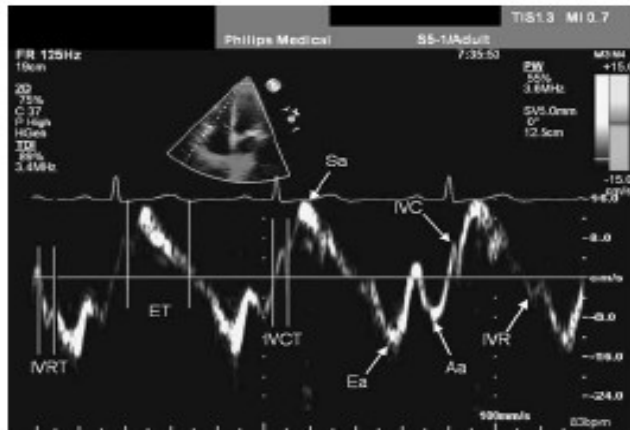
Tissue Doppler profile of the right ventricle in a healthy young adult. The normal velocities in this subject using tissue Doppler pulsed spectral imaging are: $Sa(S) = 16$ cm/sec, $Ea(E') = 15$ cm/sec, and $Aa(A') = 10$ cm/sec. Aa = late diastolic velocity; Ea = early diastolic velocity; ET = ejection time; IVC = isovolumic contraction velocity; $IVCT$ = isovolumic contraction time; IVR = isovolumic relaxation velocity; $IVRT$ = isovolumic relaxation time; and Sa = systolic velocity.
